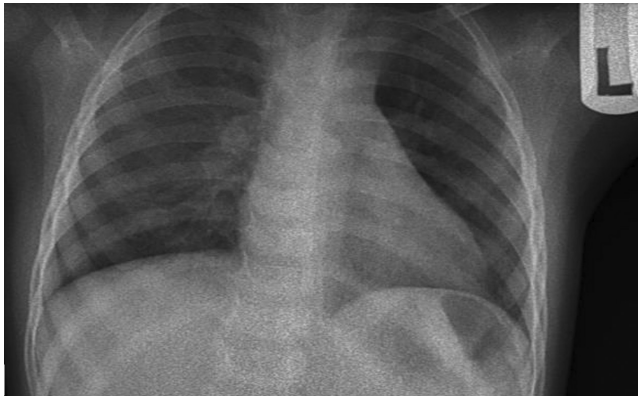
Chest x-ray of the child.
